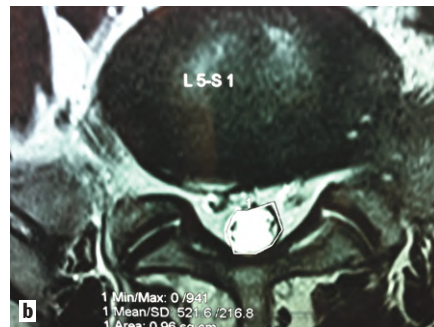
This MRI demonstrates a bulging disc with an annular tear that progressed to an eventual herniation. The patient had intermittent, but debilitating pain at this stage. Earlier definitive treatment of this condition with Disc FX or selective endoscopic discectomy would have mitigated the years of prolonged and debilitating symptoms.
